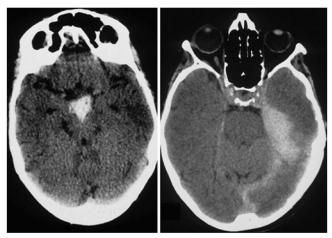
Left: Axial CT scan showing an anterior perimesencephalic SAH in a 21-year-old woman with CN III palsy that became completely asymptomatic. Right: Axial CT scan demonstrating a tentorial subdural hematoma affecting the CN IV in a 53-year-old man who partially recovered from a vertical diplopia in the 3rd month of follow-up.
